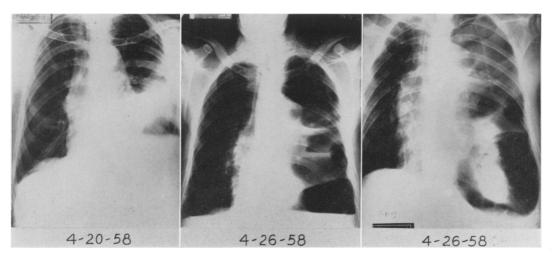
Roentgenograms of the chest of a 76-year-old man whose spontaneous perforation of the esophagus went unrecognized for six days. Air in the mediastinum, fluid and air in the pleural space with multiple fluid levels are demonstrated. The esophageal perforation was demonstrated by use of Lipiodol.
